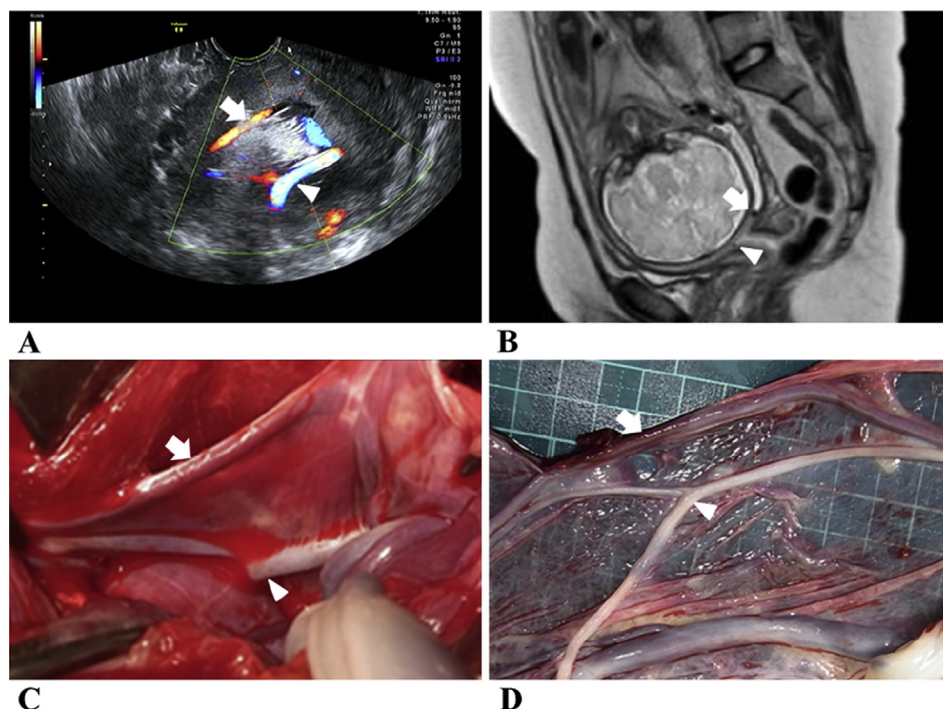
Preoperative and postoperative findings of vasa previa; umbilical vein (arrow) and artery (arrow head) were detected in each image. (A) Transvaginal ultrasonography; two vessels were detected above the internal os in axial view of the uterine cervix; (B) T2-weighted sagittal image of magnetic resonance imaging; (C) operation view; (D) macroscopic finding of placenta.
